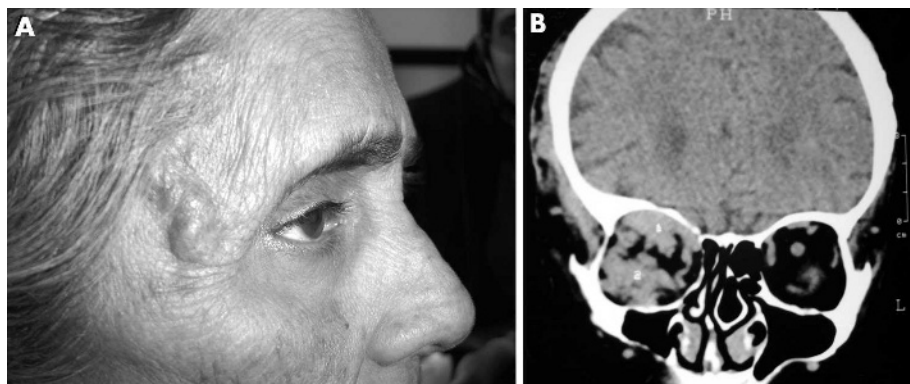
(A) Clinical picture showing distended and tortuous temporal vein; (B) CT orbit showing venous angioma situated in the right orbit. Informed consent was obtained for publication of this figure.
